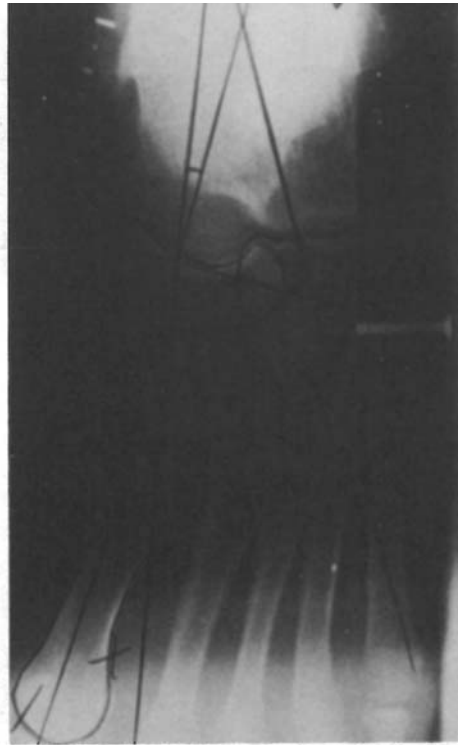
A dorsiplantar radiograph.
